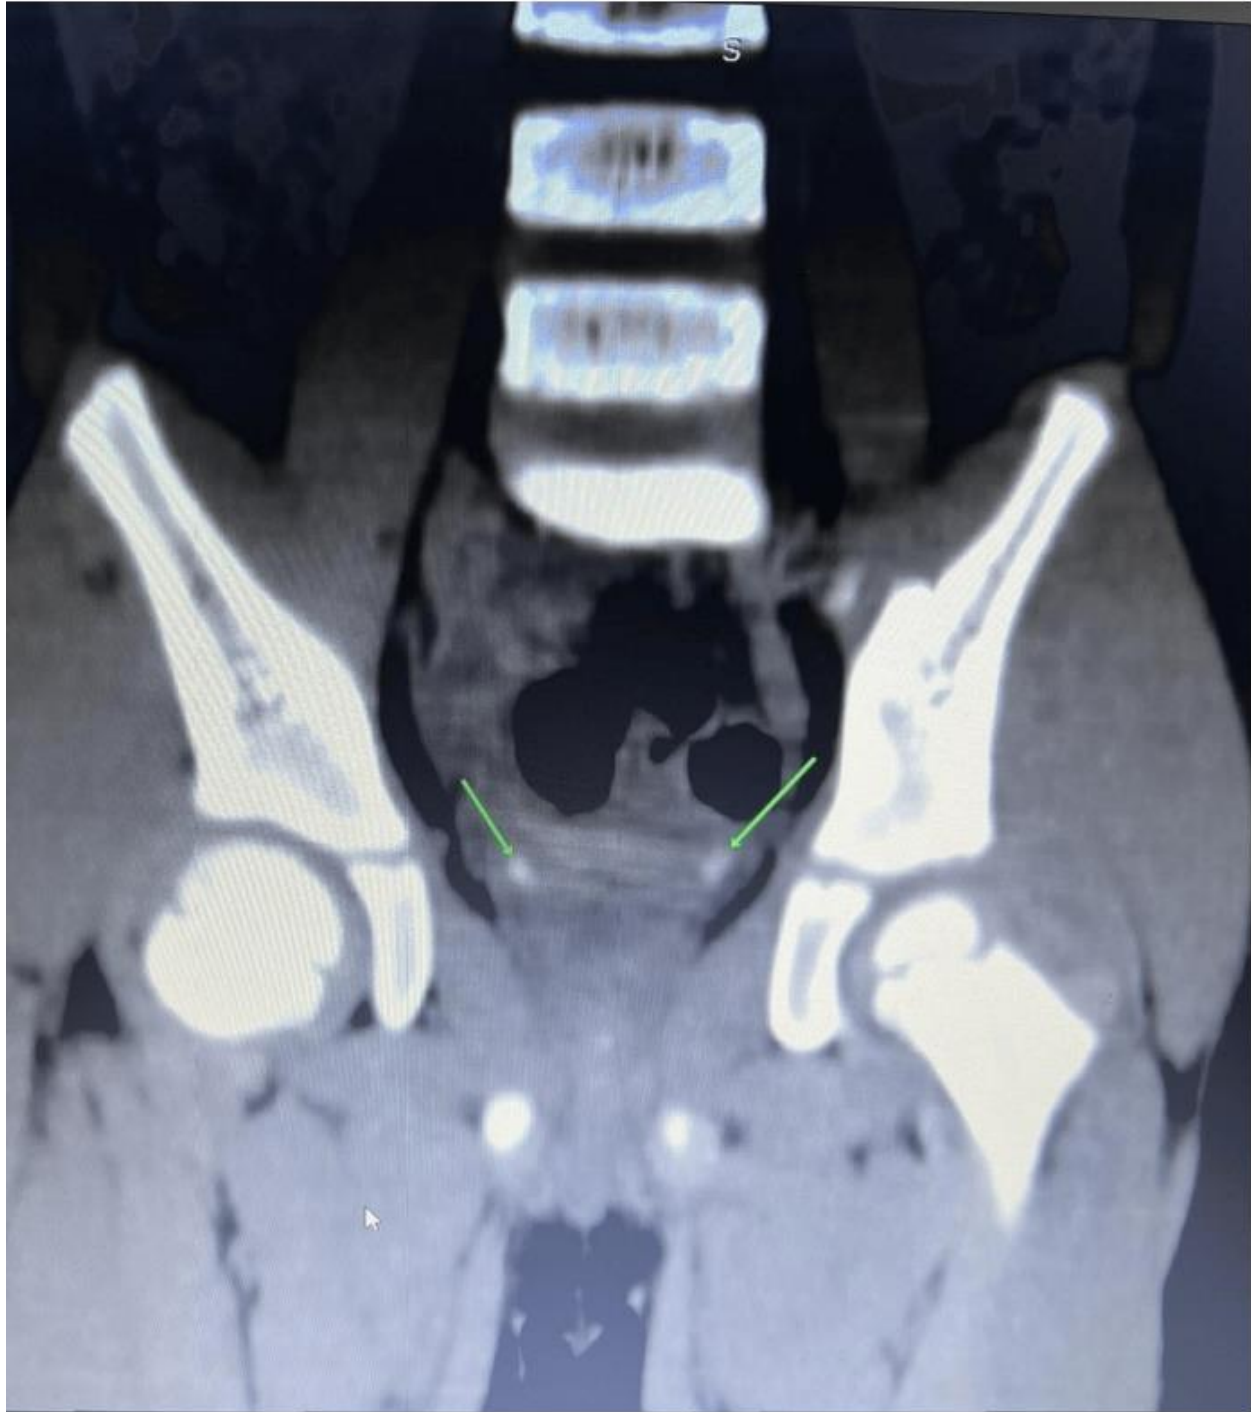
CT scan of the patient.
